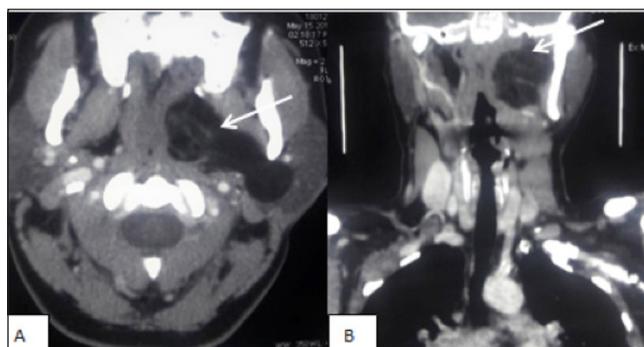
Cervical CT: A- Axial section, B- coronal section: showing a homogenous low-attenuation mass in the prestyloid space extending to the deep lobe of the parotid gland
